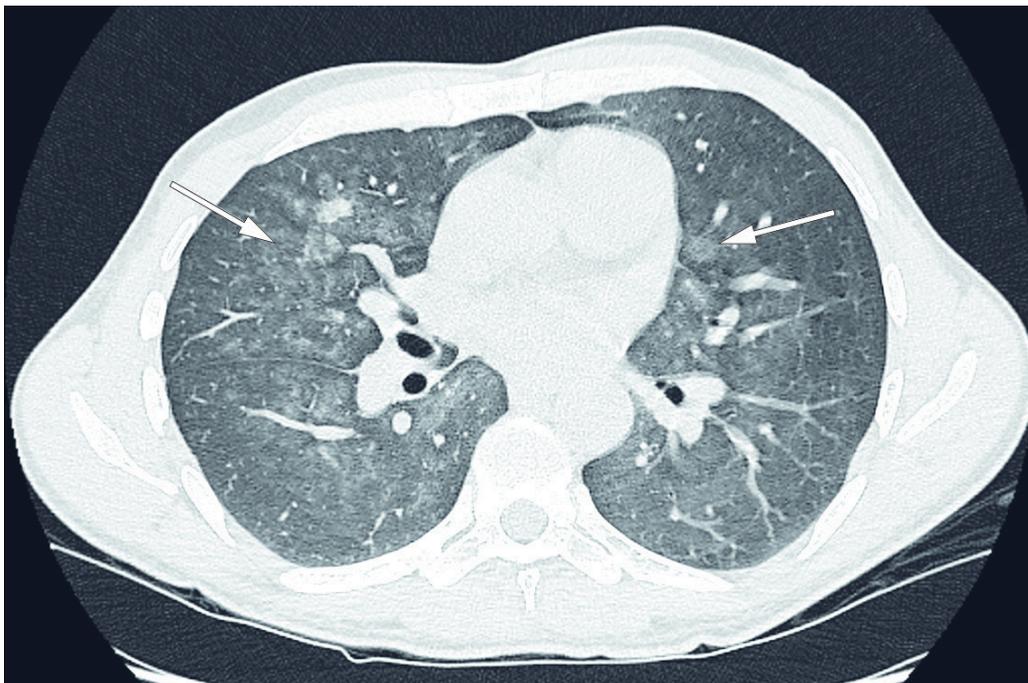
CT of the lungs with patchy, bilateral ground glass opacities (arrows).
